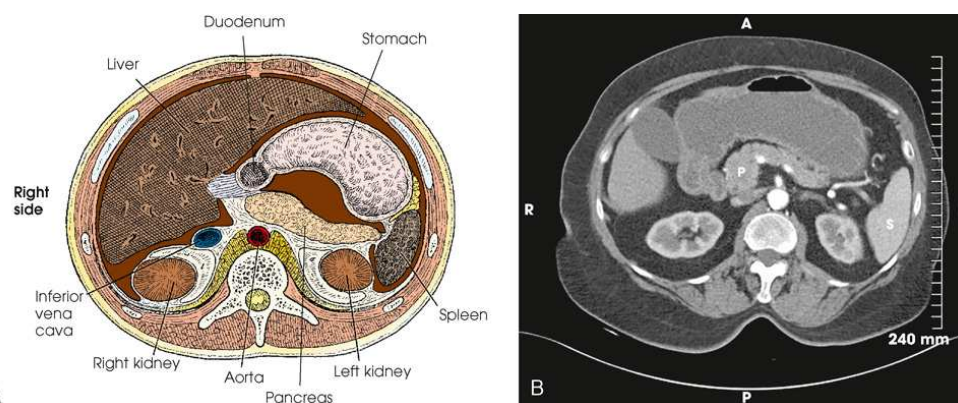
(A) Sectional image of upper abdomen (viewed from the patient's feet upward), showing relationship of digestive system components. (B) Axial CT image of abdomen, demonstrating pancreas (*P*) and the spleen (*S*). Courtesy NEA Baptist Memorial Hospital, Jonesboro, AR.
